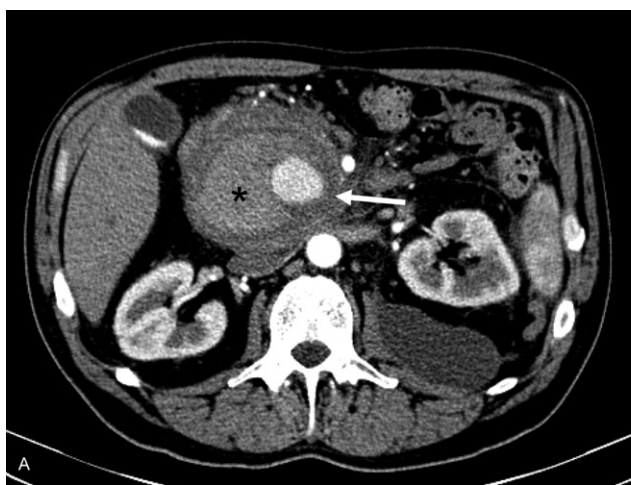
A 57-year-old man with a history of alcohol abuse and chronic pancreatitis presented with acute abdominal pain and fever. (A) Axial arterial phase CTA image demonstrates a pseudoaneurysm of gastroduodenal artery (arrow). Note the slow filling of the partially thrombosed portion of the pseudoaneurysm (*). (B) CA shows the saccular pseudoaneurysm with a narrow neck (open arrow).
